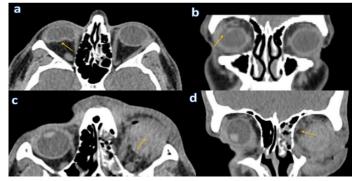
Cases of globe perforation: 1a. 33 years old male patient with blunt trauma to the right eye showing irregularity in the posterior contour of the globe on axial CT image (arrow) 1b. Coronal CT image shows a globe posterotemporal defect consistent with perforation (arrow) 1c. Axial CT image of a 15-year-old male patient portrays increased vitreous density consistent with hemorrhage after trauma (arrow) 1d. Coronal CT image of the same patient shows an intra-glob air focus (arrow) and contamination of the fat planes
